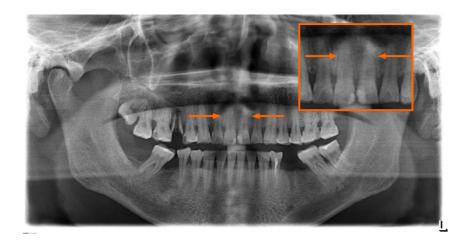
Pre-operative panoramic radiograph. The orange arrows point to the suspected fracture line.
